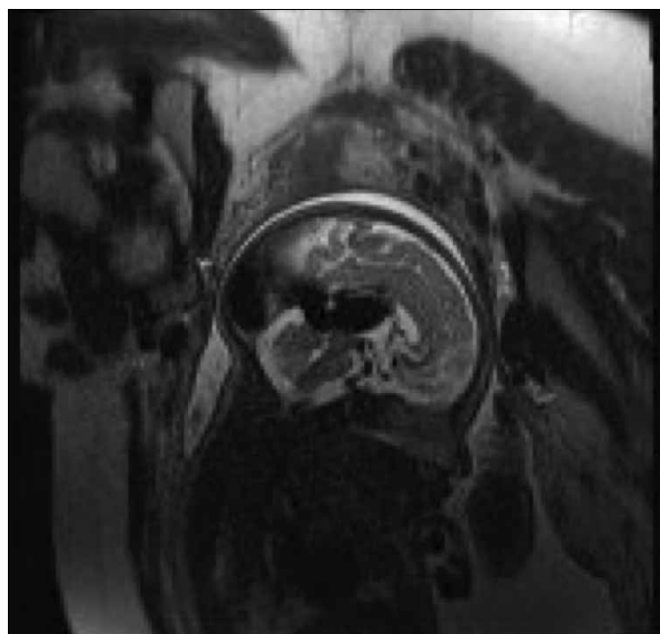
T2-weighted Fetal Magnetic Resonance Image
